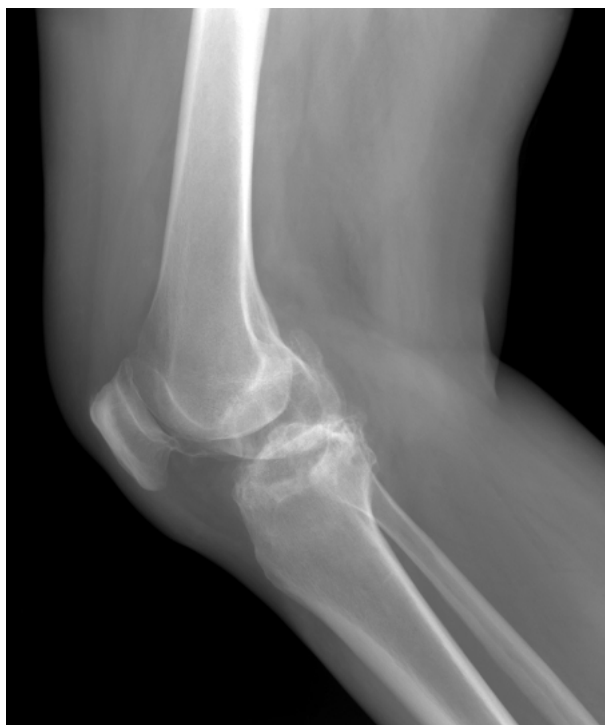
Left knee preoperative lateral radiograph demonstrating end-stage varus gonarthrosis.
